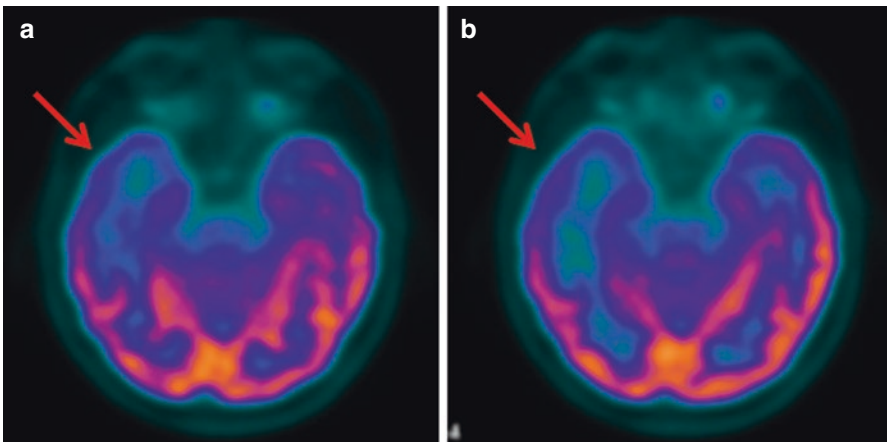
(a–d) A 30-year-old patient with non-lesional right frontotemporal lobe epilepsy. Axial ^{18}F FDG PET (a, b) and fused ^{18}F FDG PET/MR (c, d) show perfect agreement between the two techniques with area of hypometabolism in the right temporal lobe (a–d, arrows) representing an epileptogenic focus.
